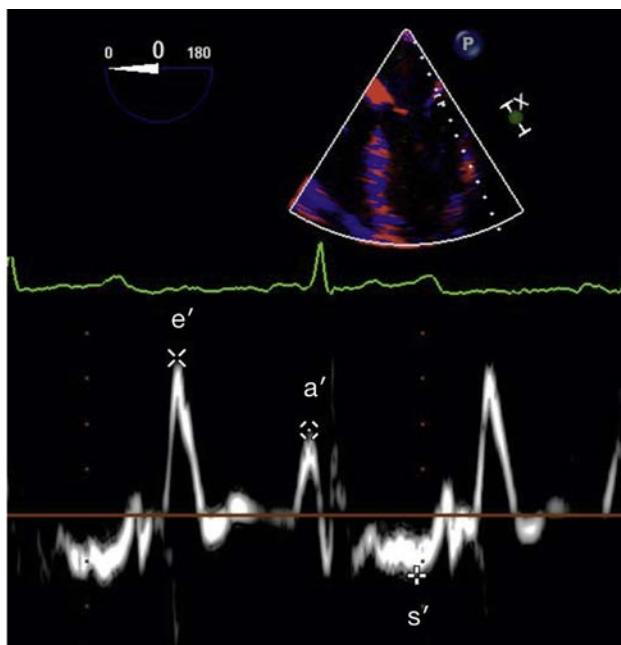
Spectral Doppler tissue imaging obtained at the lateral mitral annulus in the midesophageal four-chamber view. The systolic waveform (s') corresponds to the systolic tissue velocity. The two diastolic waveforms correspond to the early diastolic tissue velocity (e') and the late (atrial) diastolic tissue velocity (a'). When obtained using TEE, s' is a negative waveform (directed away from the transducer), while e' and a' are positive waveforms. Transthoracic acquisition of mitral annular velocity is performed in the apical four-chamber view. In TTE acquisition, the s' waveform is positive, while e' and a' are negative.
